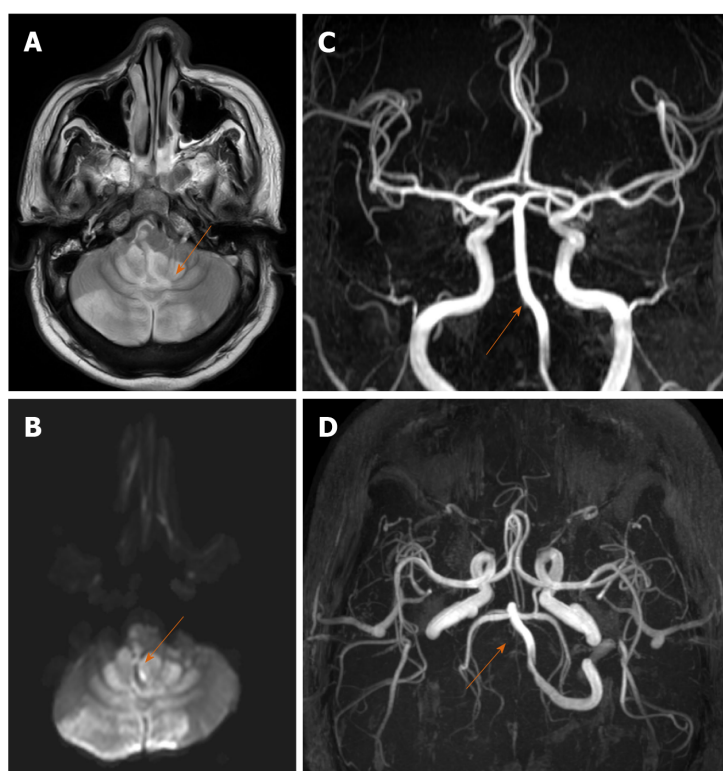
A 35-year-old male with posterior circulation stroke. A and B: Axial sections of magnetic resonance imaging brain (T2W, diffusion sequences) show areas of high signal in both cerebellar hemispheres, vermis and brainstem suggestive of acute infarcts; C and D: Magnetic resonance artery coronal and axial sections show complete non visualization of right vertebral artery (arrow) suggestive of thrombosis.
